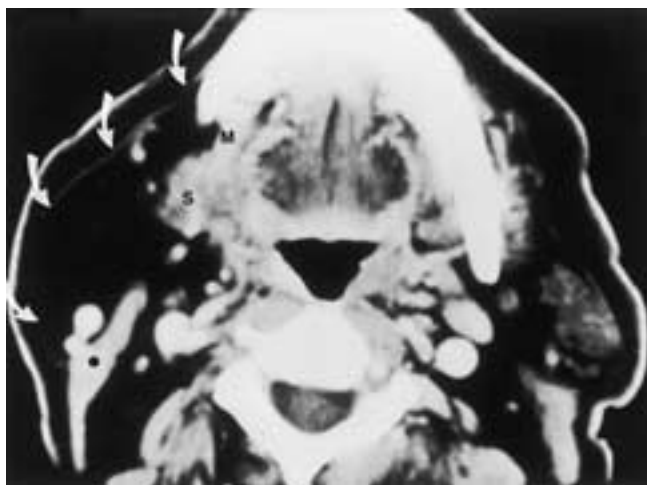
Lipoma. Contrast-enhanced CT scan reveals a large lipoma within the right submandibular space. The fat-density lesion is virtually impossible to distinguish from the subcutaneous fat, although it is separated by thin fibers of the platysma muscle (arrows). The lesion insinuates among the normal structures of this region. S, Submandibular gland; black dot, sternocleidomastoid muscle; M, mylohyoid muscle.
